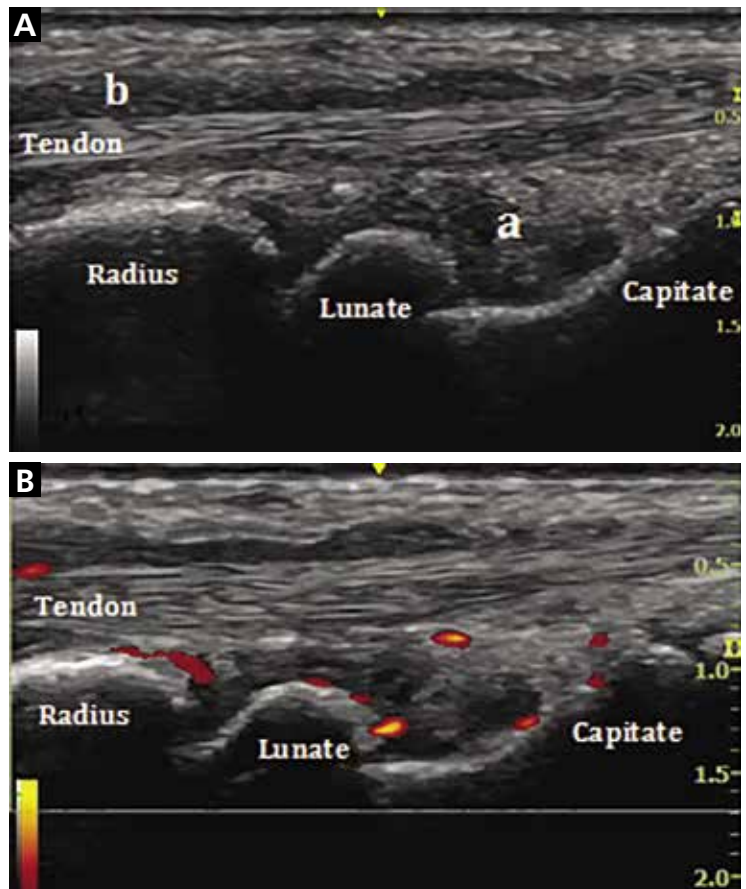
Musculoskeletal ultrasonography demonstrates wrist synovitis and extensor tendon tenosynovitis. In A, a grayscale longitudinal view of the wrist shows synovial hypertrophy (a) along with extensor tendon tenosynovitis (b). In B, power Doppler of the wrist shows active inflammation in the synovium (synovitis) and the extensor tendon sheath (tenosynovitis).
